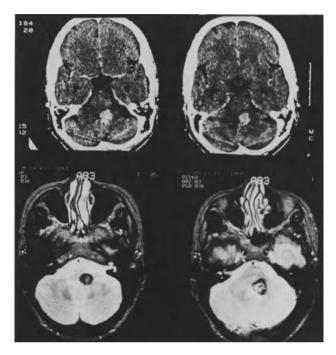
CT scans and T2-weighted MR images of a lesion in the dorsal pons of 51-year-old woman who presented with a slowly progressive pontine syndrome. The MR images show the hemosiderin around the lesion
